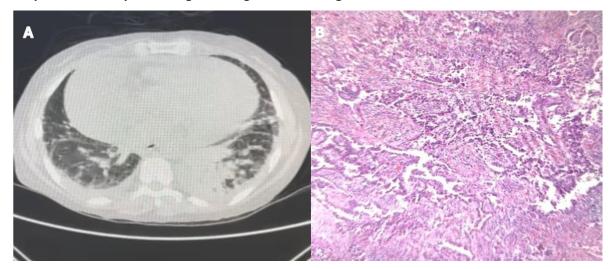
A) Plain chest CT scan showing massive pericardial effusion, minimal left pleural effusion, and left lung lesion.
